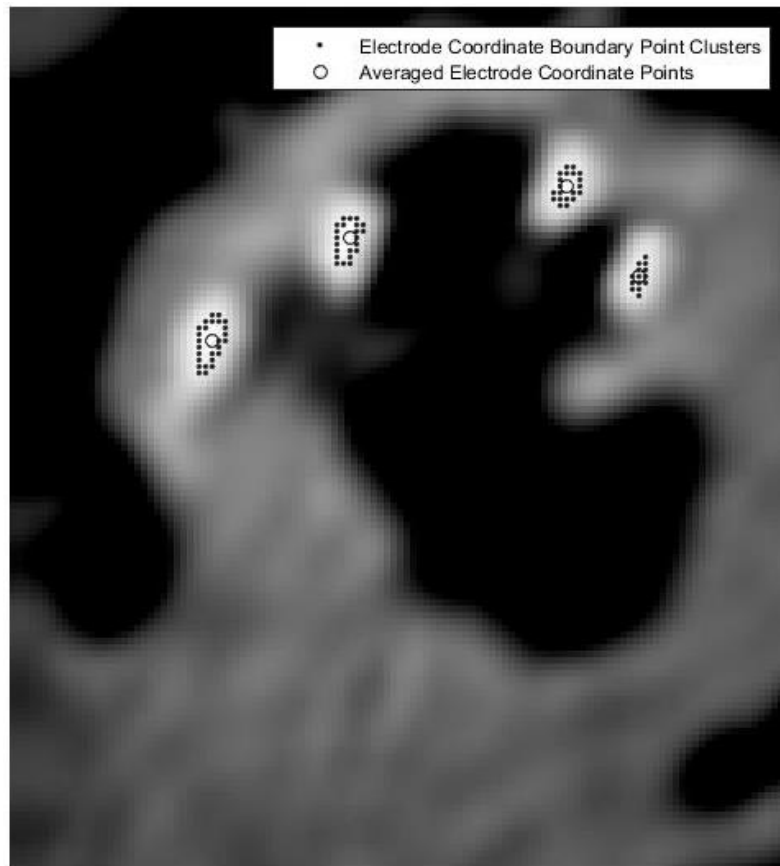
Example of electrode contacts detected on a CT image through intensity thresholding and which are used to construct the spiral coordinates that describe the intra-cochlear trajectory of the electrode array. This electrode was inserted to an angle greater than 541° .
